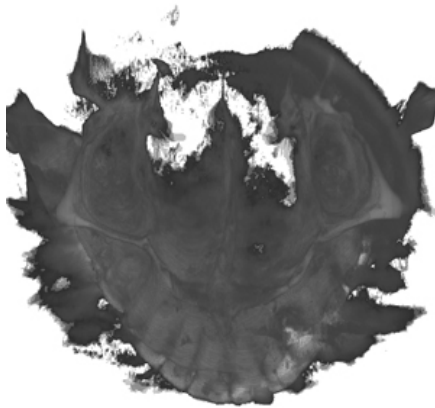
Top-bottom view of a raw CBCT volume.
